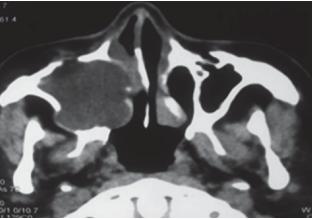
CBCT image of a mucocele opacifying the right maxillary sinus with medial bulging causing sinus expansion and obstruction of the right nasal cavity
